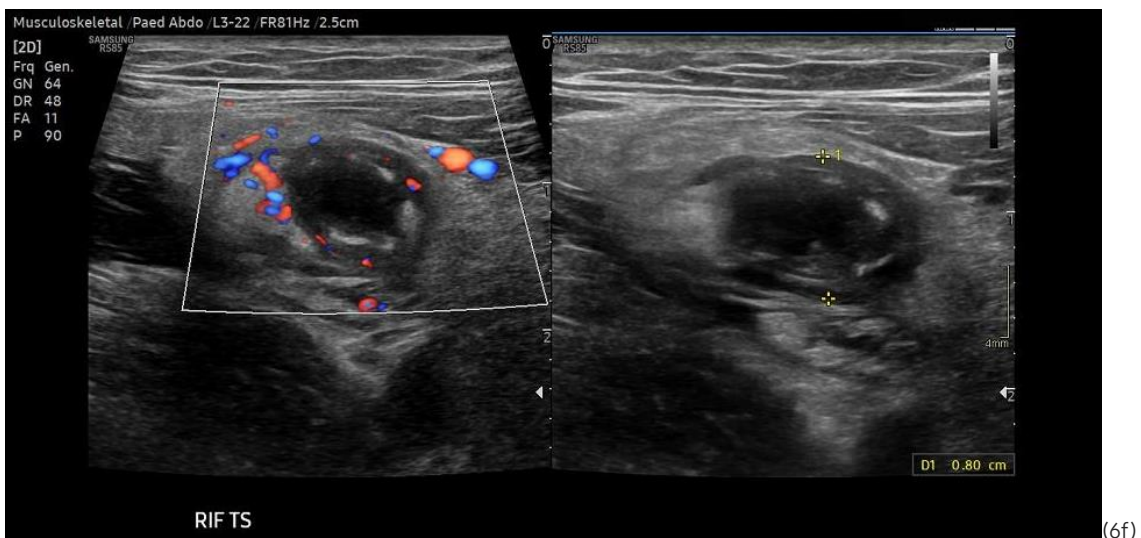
The ultrasound image shows a transverse view (TS) of the right iliac fossa (RIF), of the above acute appendicitis. The appendix is dilated measuring 8 mm in diameter, upper limits of normal appendix diameter 6-7mm. [3][12] The TS images confirm a noncompressible tubular structure, with hyperaemia and surrounding echogenic fat, consistent with inflammation.
